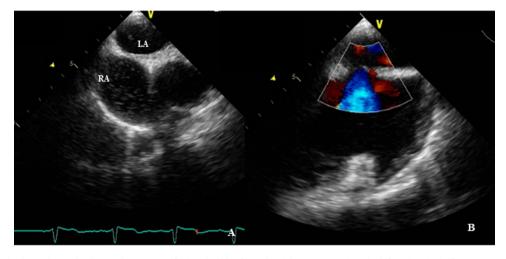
Transoesophageal echocardiography detected crossover of micro bubbles from the right atrium (RA) to the left atrium (LA) after intravenous injection of agitated saline (A). A right to left shunt was suggested by color Doppler analysis (B).
